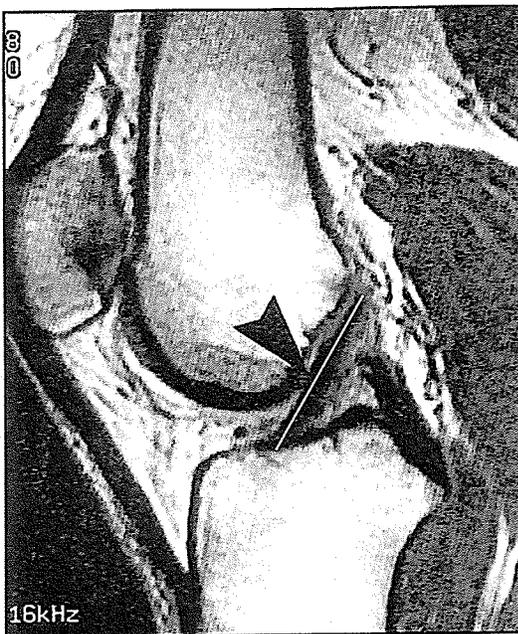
Magnetic Resonance Image (Sagittal Oblique View) of the ACL and Measurement of Ligament Length. (Friedman and Jackson, 1996).
